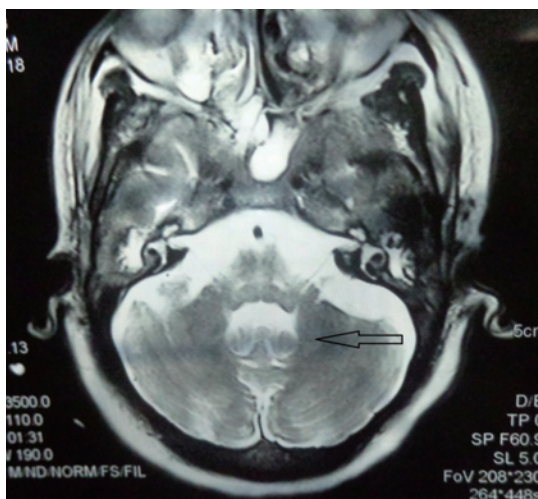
T2 weighted MRI of the brain showed hyperintense lesions in pons.
